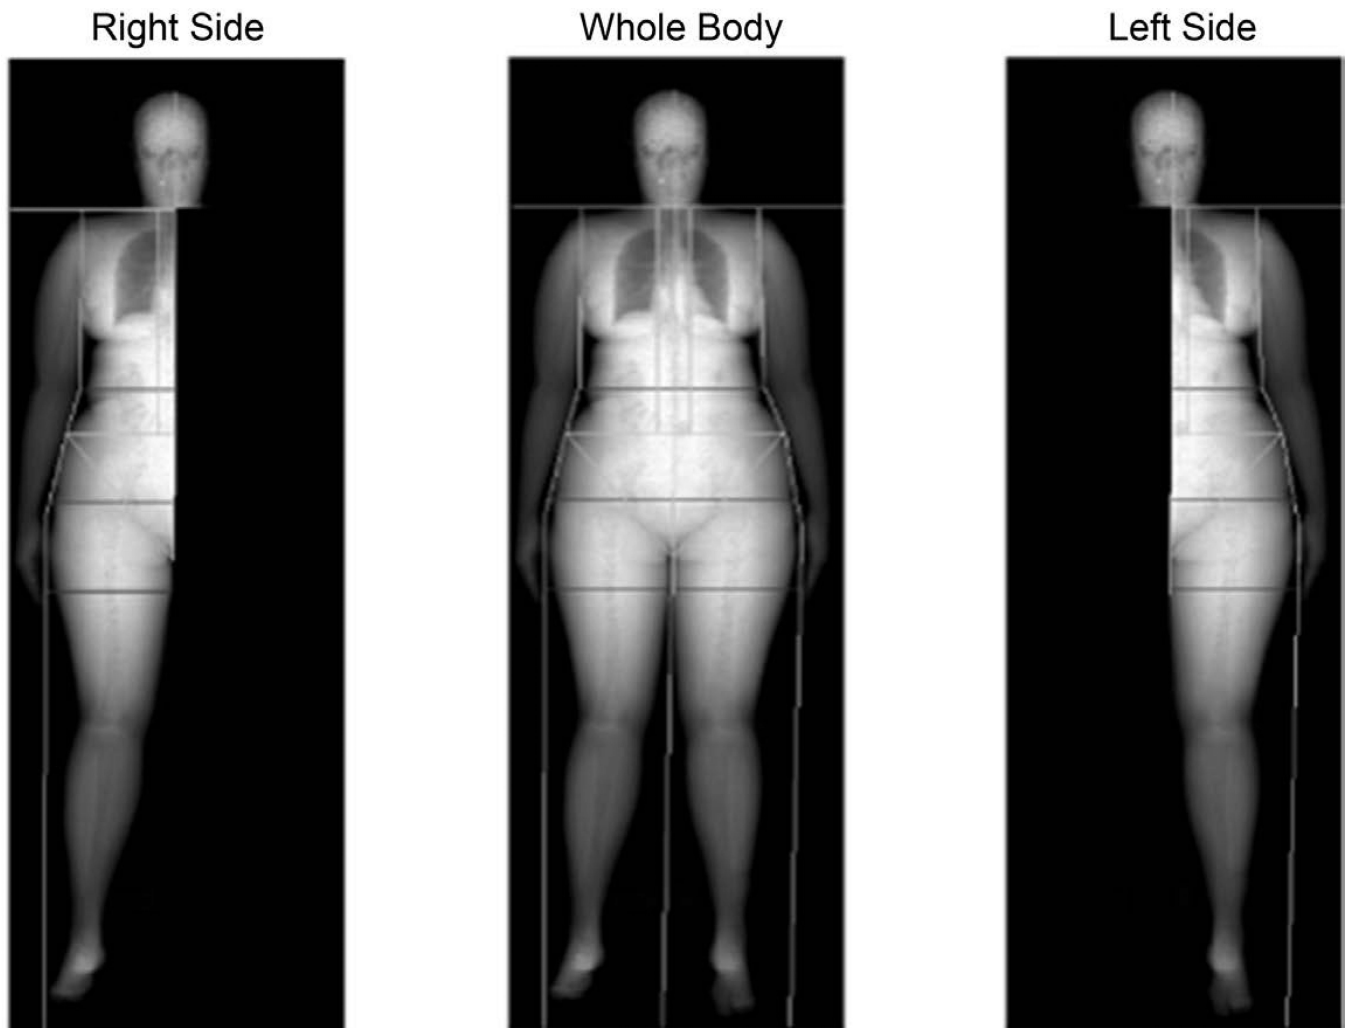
Body composition measured by dual-energy X-ray absorptiometry half-body scans in obese children. Example of iDXA total-body composition image and a representation of the portions of the total-body image used to generate the right side and left side images. (Reproduced from ref 9)
